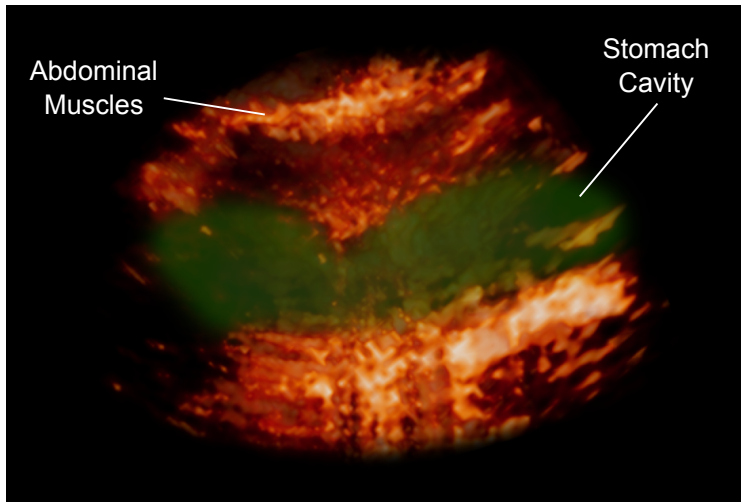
3D reconstruction of the stomach at 4 Hz sinusoidal input. 37 ultrasound images were acquired from 0 to 180 degrees at 5 degree intervals. The stomach cavity is shaded in green.
